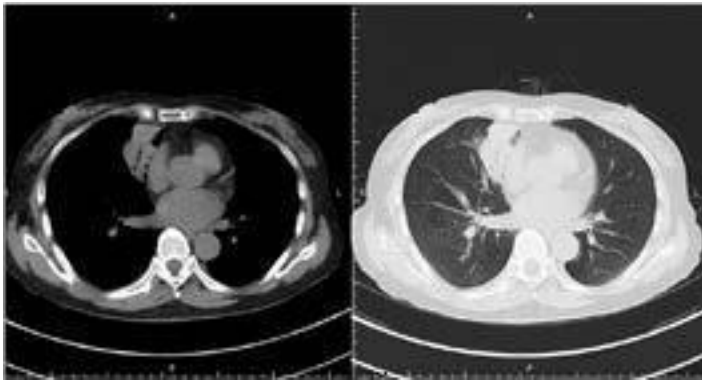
Chest computed tomography shows bilateral pleural thickness, consolidation in right middle lobe and small nodules in right upper lobe.
